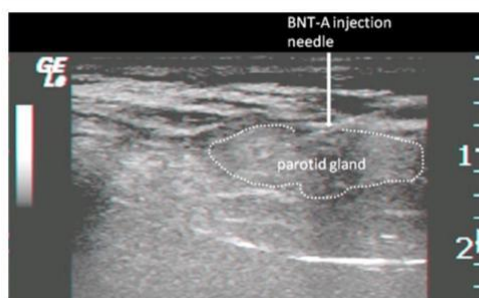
The ultrasound sonography of BNT-A injection to the salivary gland
